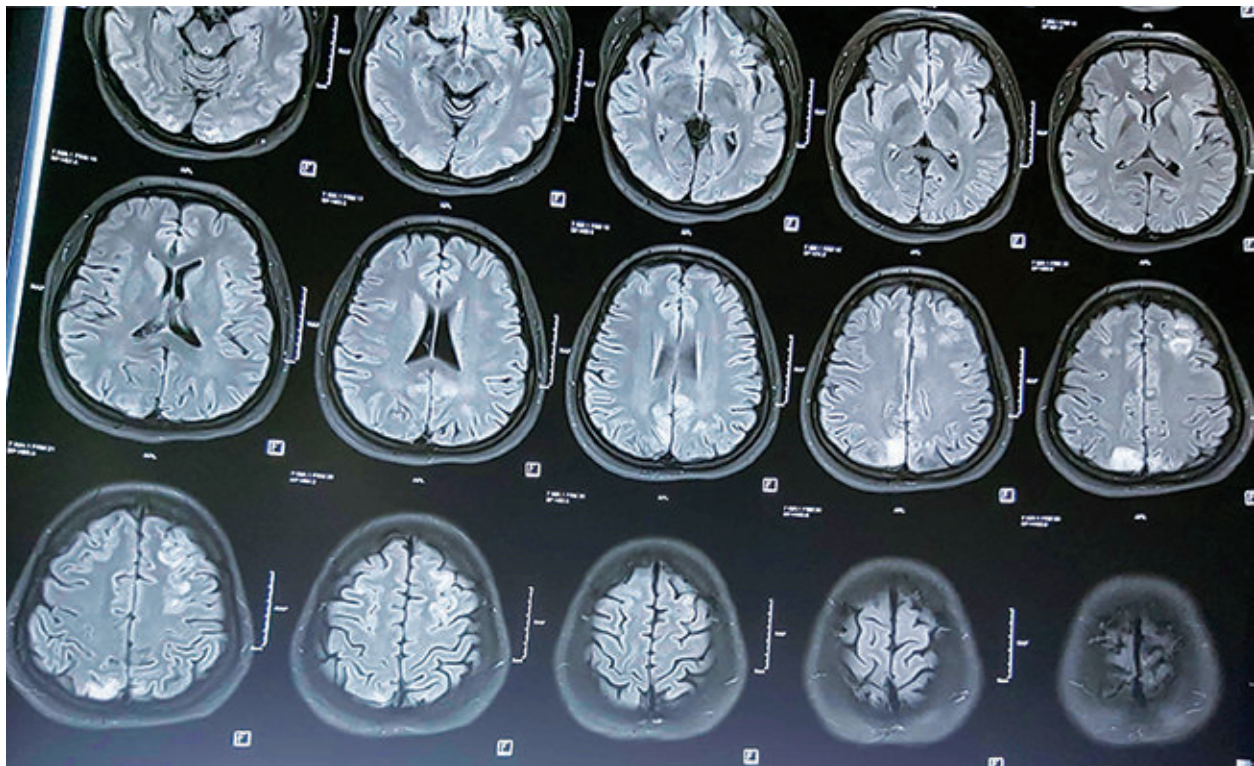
Fluid-attenuated inversion recovery (FLAIR) image of brain MRI showing hyperdensities in the cortex and subcortical white matter of right occipital lobe consistent with posterior reversible leukoencephalopathy syndrome.
